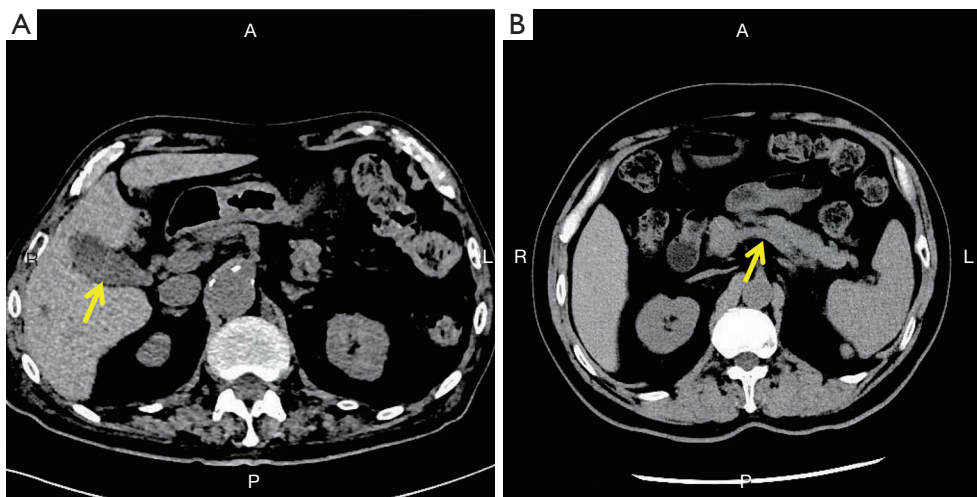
Abdominal computed tomography scans. (A) The gallbladder (marked by the yellow arrow) was 8.6×3.2 cm² in size, and there were no palpable stones in the gallbladder. (B) The pancreas (marked by the yellow arrow) is morphologically normal, uniform in density, and there is no peripancreatic exudate.
